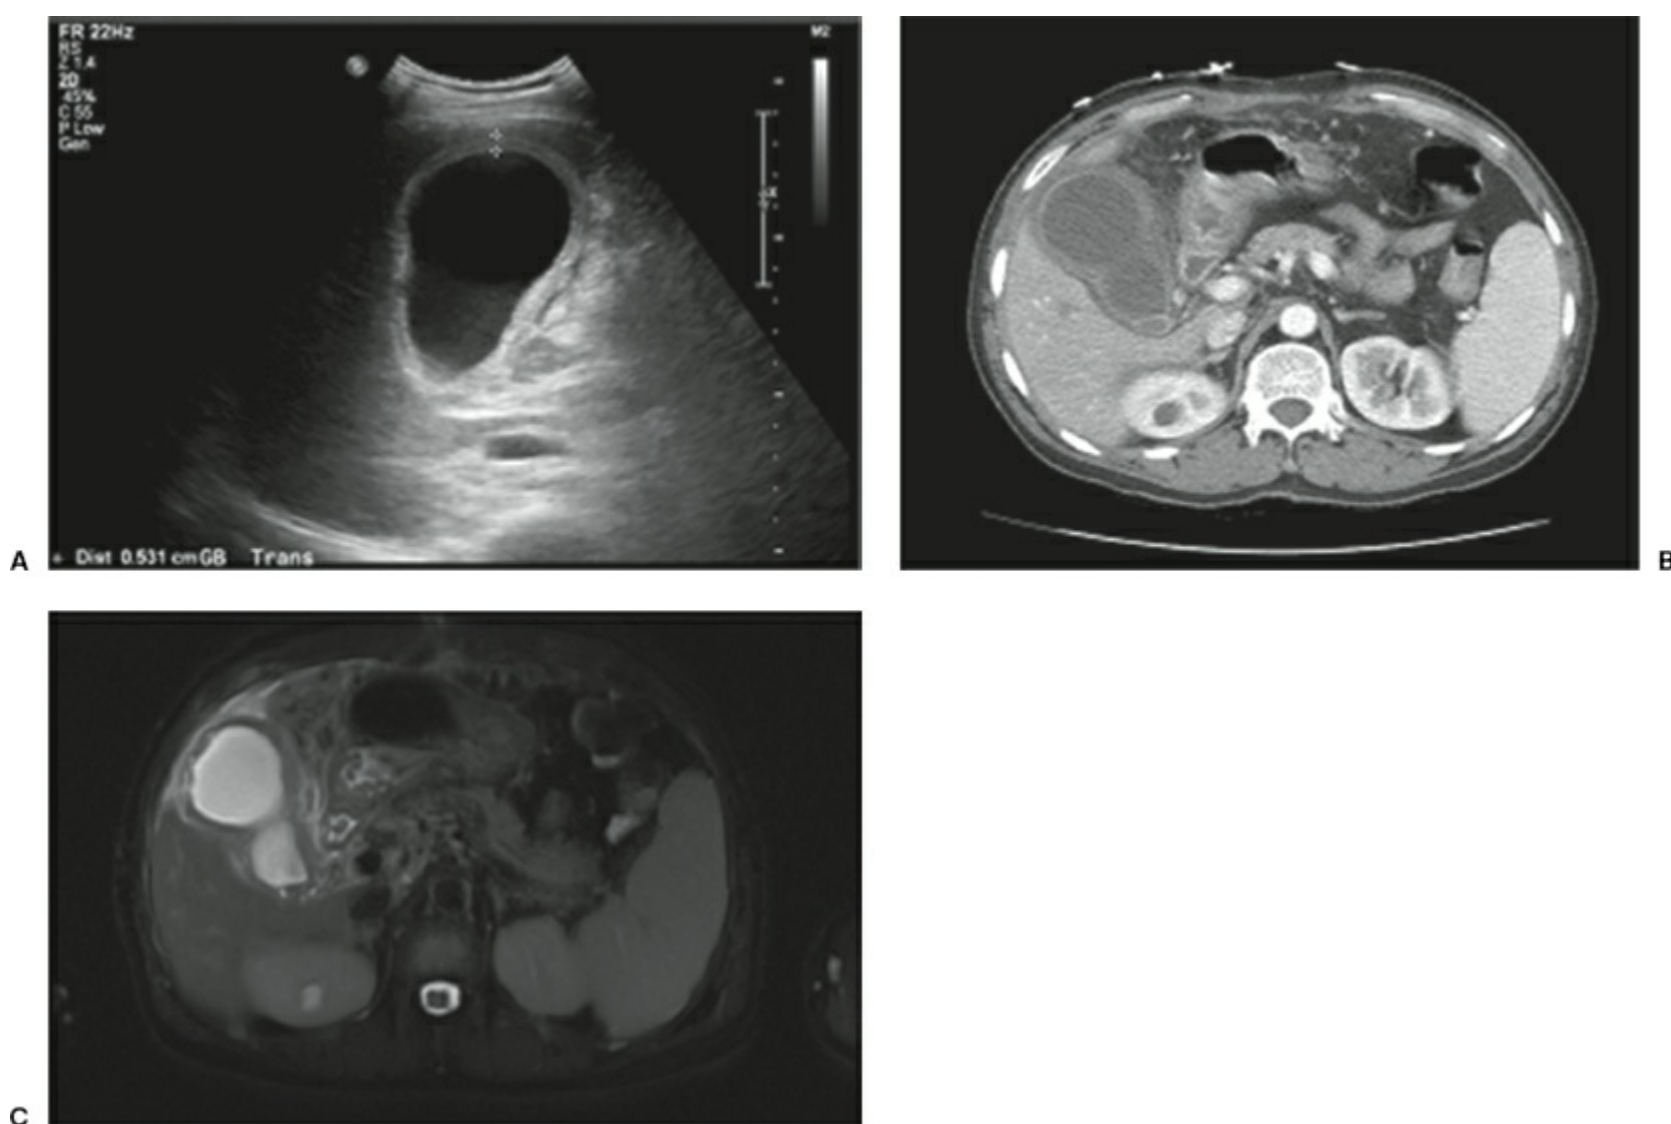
Classic acute cholecystitis seen on US (A) with luminal distention, gallbladder wall thickening >5 mm, and pericholecystic fluid; CT scan (B) demonstrates similar findings of wall thickening and pericholecystic stranding; MRI T2 fat-saturated sequence (C) demonstrates gallbladder wall edema and pericholecystic fluid, as well as small stones in the gallbladder neck. (Image courtesy of Aarti Sekhar, MD and David Schuster, MD, Emory University Department of Radiology.)
